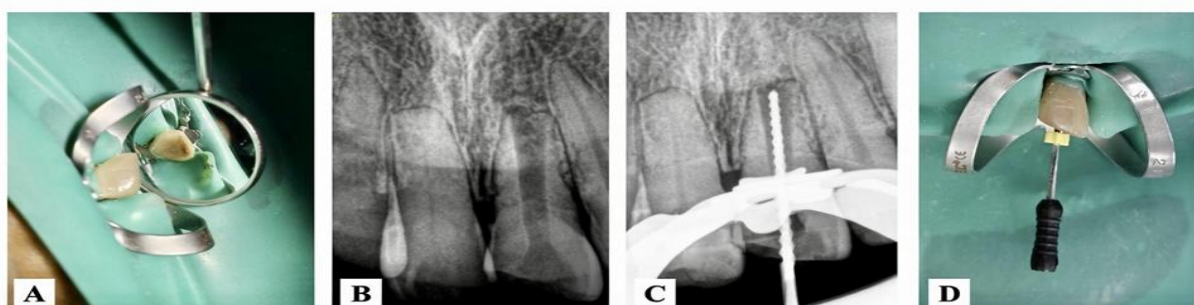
Preoperative assessment and working length determination. (A) Clinical view of tooth #21 after access opening under rubber dam isolation. (B) Preoperative radiograph showing immature root apex with associated periapical radiolucency. (C) Working length determination radiograph using endodontic file. (D) Clinical view of working length estimation under rubber dam isolation
